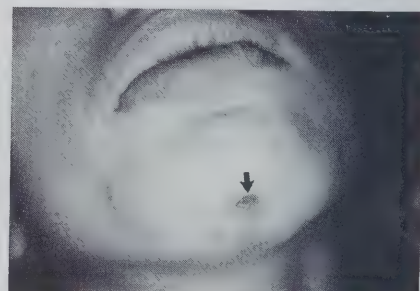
(Case 8). Sinus opening in the skin from periapical infection of the lower centrals. The scar from three previous attempts at extraoral excision is evident.
